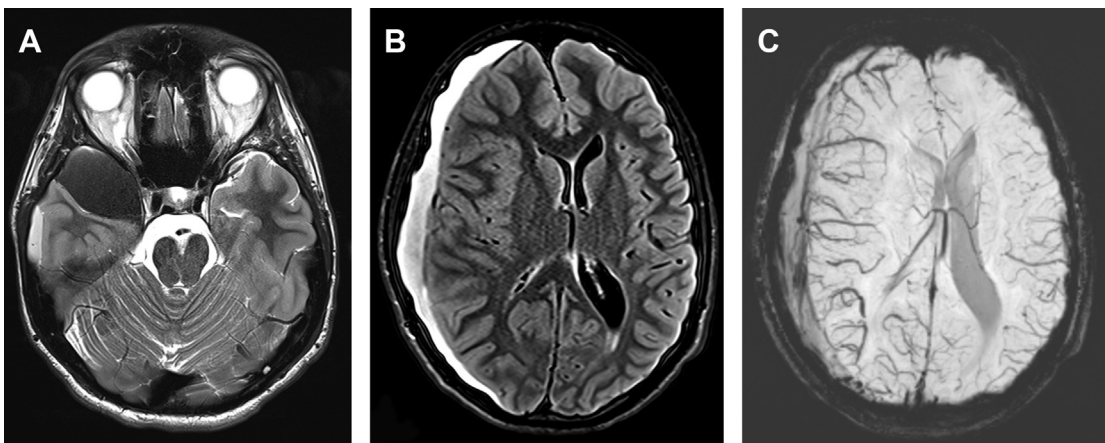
A 17-year-old boy with 2 months of headache, presenting with worsening headache and vomiting due to hemorrhage complicating an arachnoid cyst. Axial T2-weighted MR image (A) demonstrates a right middle cranial fossa arachnoid cyst containing hypointense blood products. Axial FLAIR (B) and SWI (C) demonstrate a right holoheemispheric subdural hematoma with mass effect and venous congestion in the right cerebral hemisphere.
